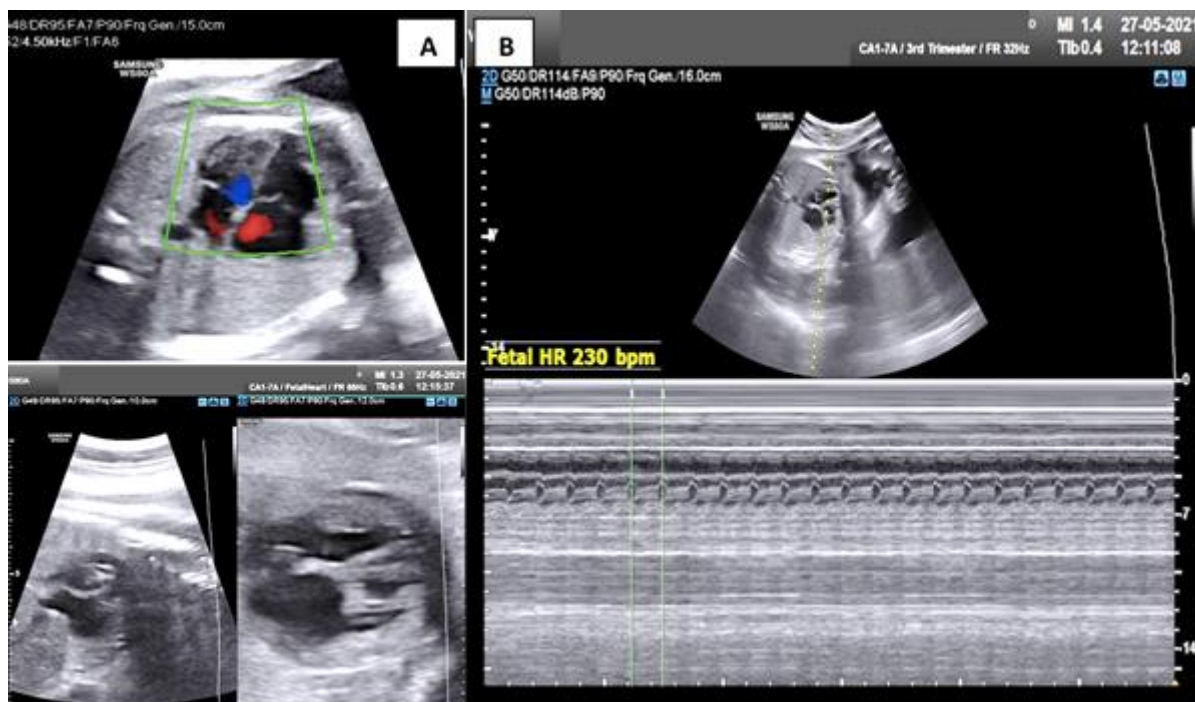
M-mode echocardiography results at Dr. Soetomo Academic Hospital (Date: May 27th, 2021). (A) The structure of the heart was normal and (B) fetal heart rate of 230 bpm
